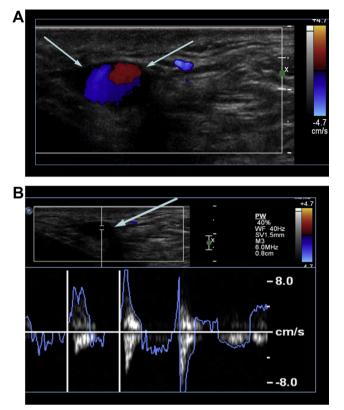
(A) Color Doppler ultrasound demonstrates blood flow within the center of the mass (arrows), presenting as yin—yang sign and (B) high-velocity antegrade and retrograde flow through a narrow vascular channel connecting it to an adjacent arterial vessel.
